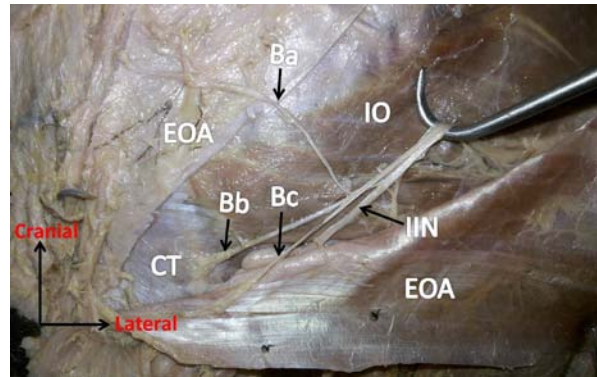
Closer view of left groin region showing the unusual path of branches of the ilioinguinal nerve (IIN). (Ba, Bb and Bc: branches of the IIN; CT: conjoint tendon; EOA: external oblique aponeurosis; IO: internal oblique muscle)
